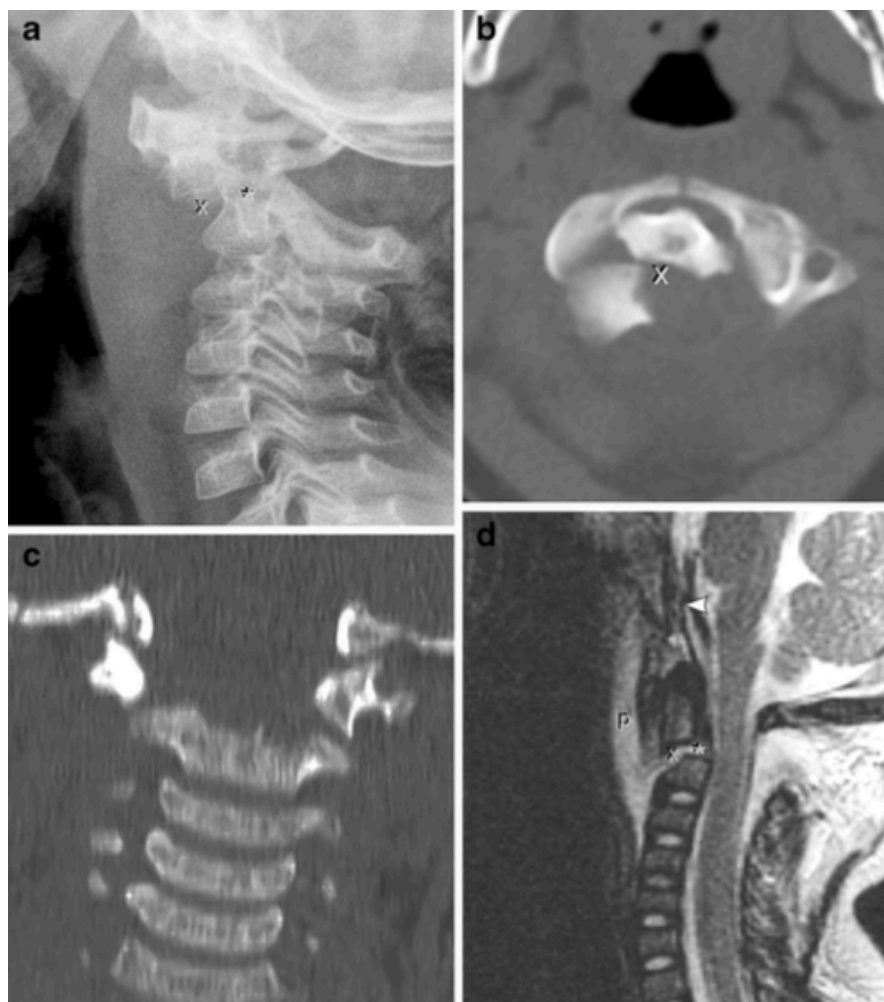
Type I subtype c fracture in patient 7, a 3-year-old girl after a motor vehicle crash. (a) Lateral radiograph and (b) axial CT images show fractures of the right and left odontoneural (arrows) and the odontocentral synchondroses (*) with 8.2 mm (>100%) anterior displacement (x), 8 deg. rotation, significant angulation (16 deg on XR [not shown], 21 deg on CT) and atlanto-occipital dissociation (C1-skull separation). (c) On coronal CT, the odontoid process appears to be absent giving it the “missing tooth” sign. (d) Sagittal T2-W MR image after attempted reduction and halo stabilization shows improved fracture alignment with anterior, posterior and apical ligamentous injury, pre-vertebral edema (p) and cord impingement. MRI also shows clival hematoma (arrowhead). Initial halo stabilization failed and this patient ultimately underwent a procedure to fuse the fracture with posterior occipital-C4 hardware.
